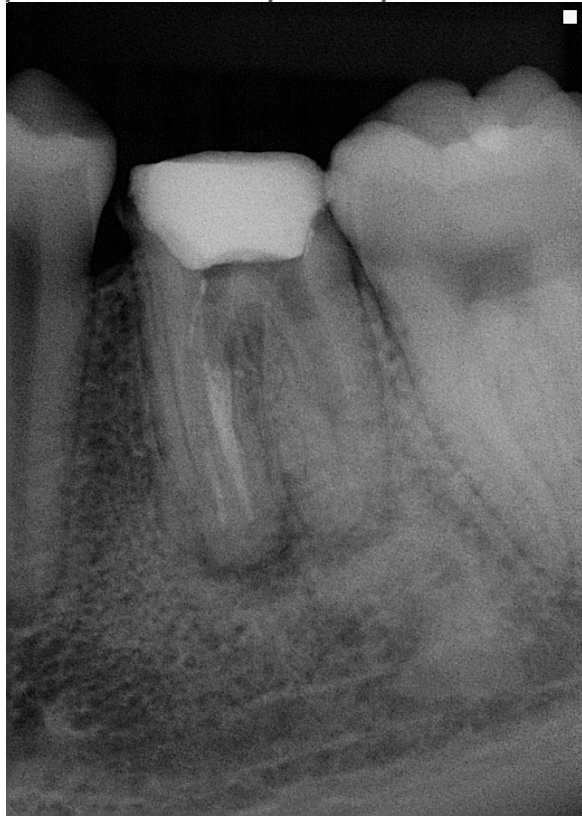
Initial Radiography
